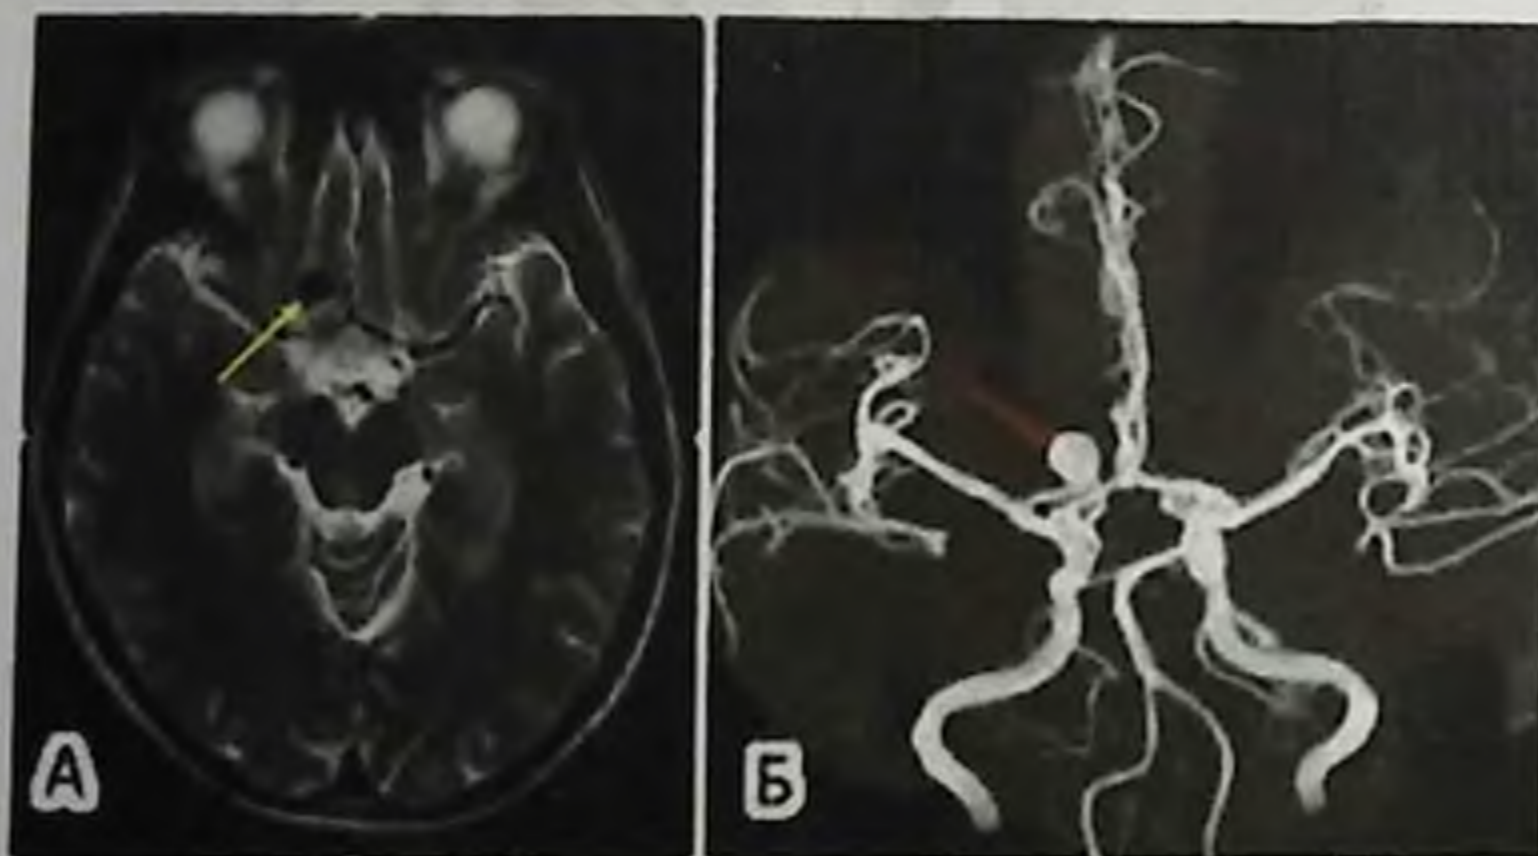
MRI of the brain. Aneurysm in basin A of the 1st part of the anterior cerebral artery of the brain.
